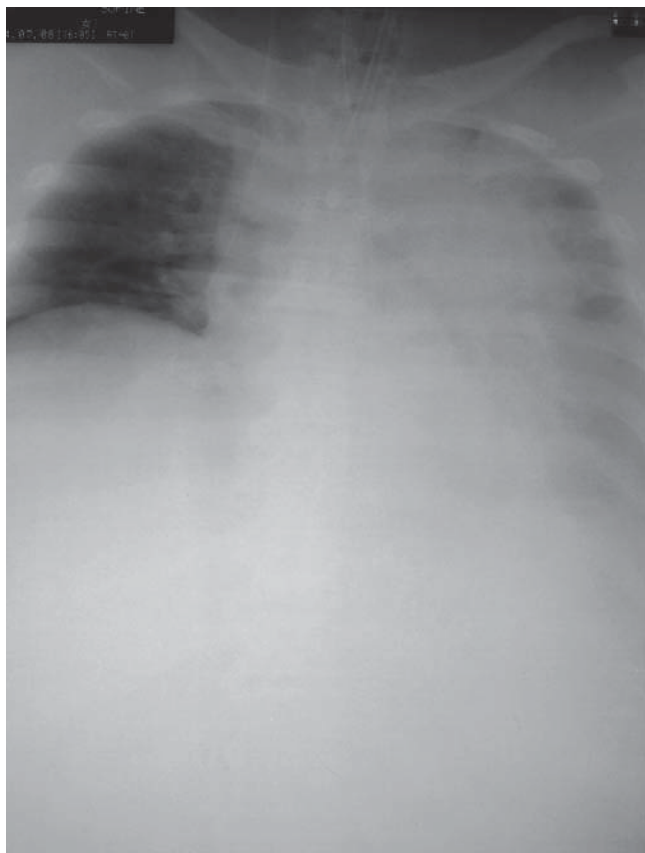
Chest X-ray film during surgery when hypoxemia and hypotension occurred. Note massive atelectasis in the left lung
